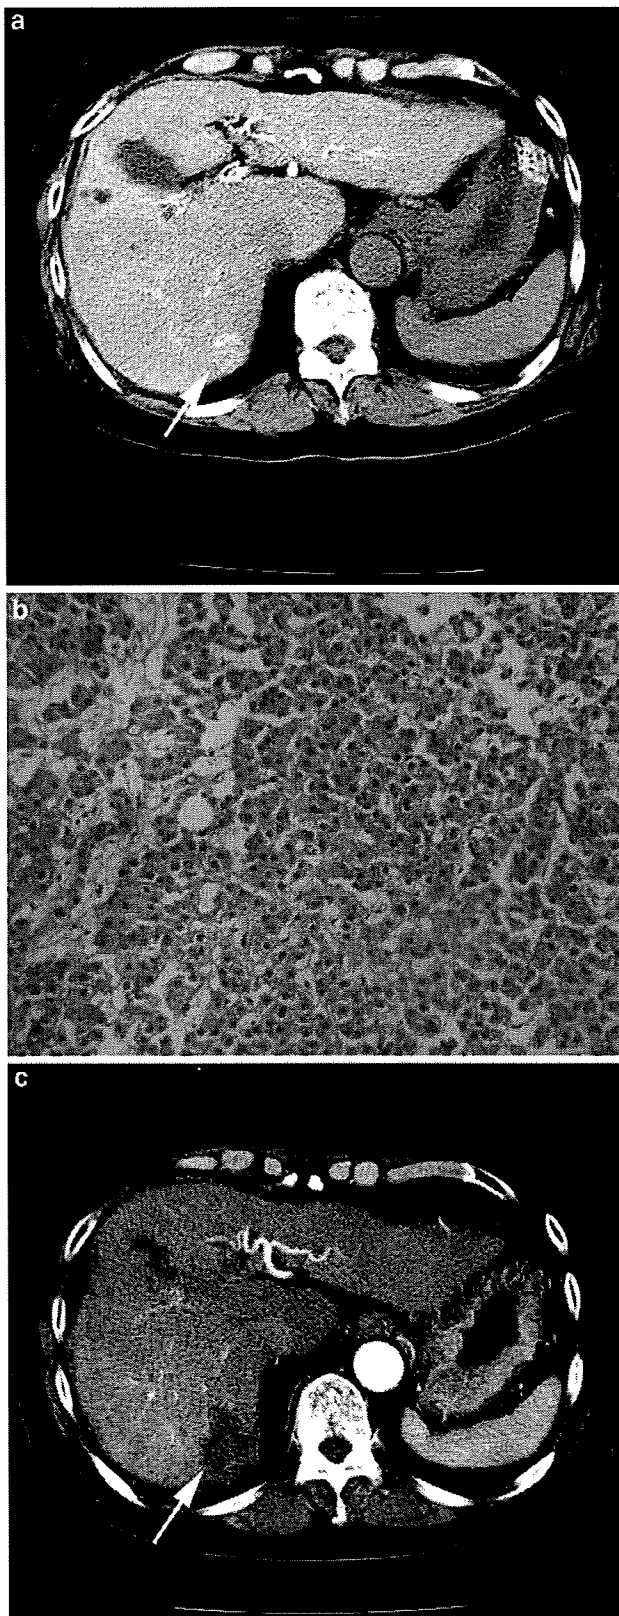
Before PEI: (a) CTA revealed slight hypervascularity (arrow); (b) well-differentiated HCC was observed. After PEI: (c) contrast-enhanced CT revealed an LDA (arrow)
